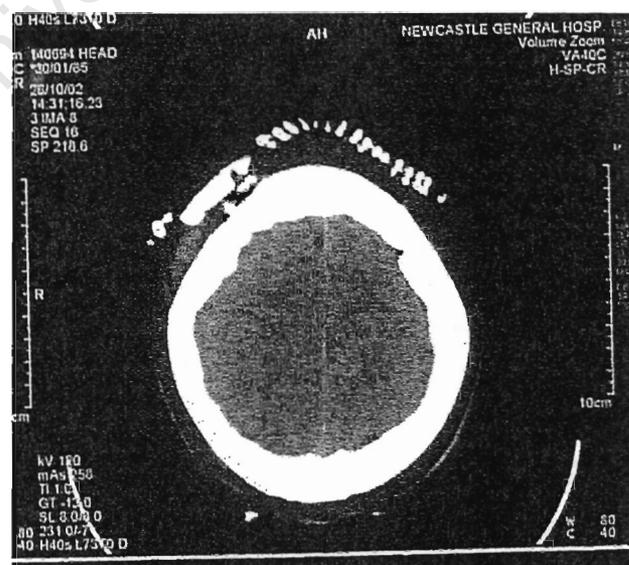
CT Head scan of patient RM
